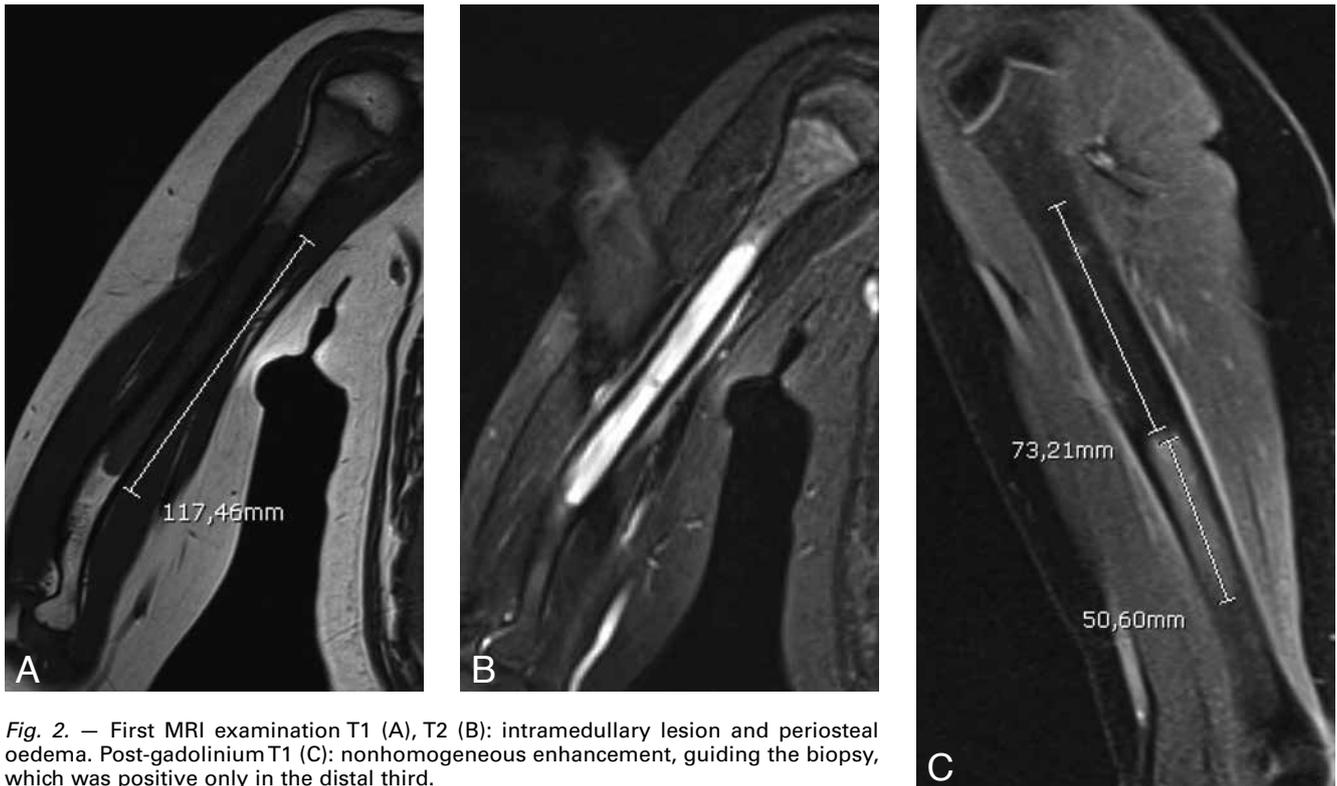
First MRI examination T1 (A), T2 (B): intramedullary lesion and periosteal oedema. Post-gadolinium T1 (C): nonhomogeneous enhancement, guiding the biopsy, which was positive only in the distal third.
